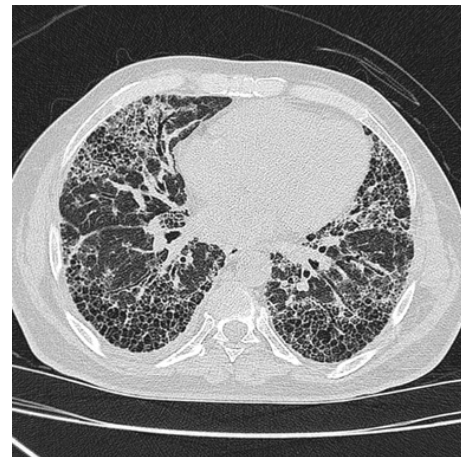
High-resolution chest CT showing basal and subpleural honeycombing with traction bronchiectasis, consistent with a Usual Interstitial Pneumonia (UIP) pattern.
